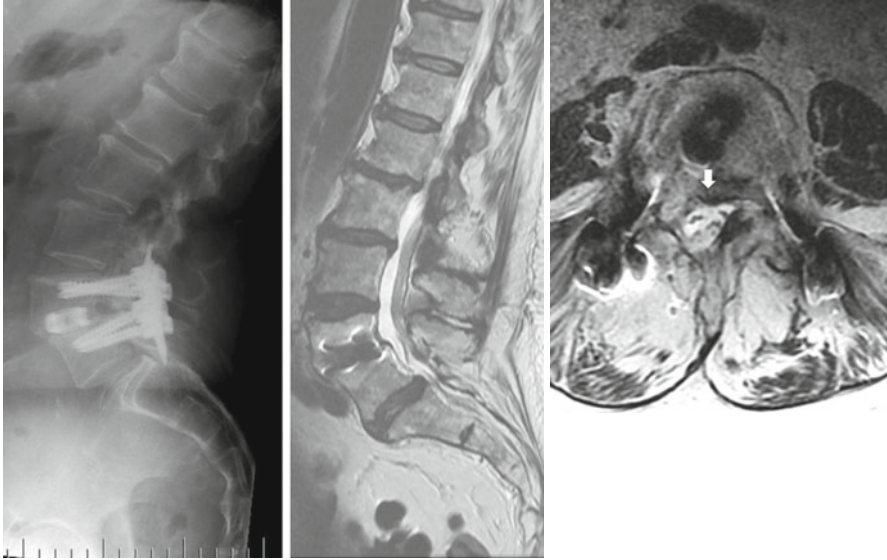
Five-year postsurgical lateral standing radiograph, midsagittal MRI, and axial MRI at L4–L5 in the same patient as in Fig. 4.2. Due to the instability, the patient required a decompression of the spinal canal (*white arrow*) and spinal fusion with instrumentation that is seen on the lateral radiograph. This resulted in dramatic reduction of her pain and improvement of her functional ability
